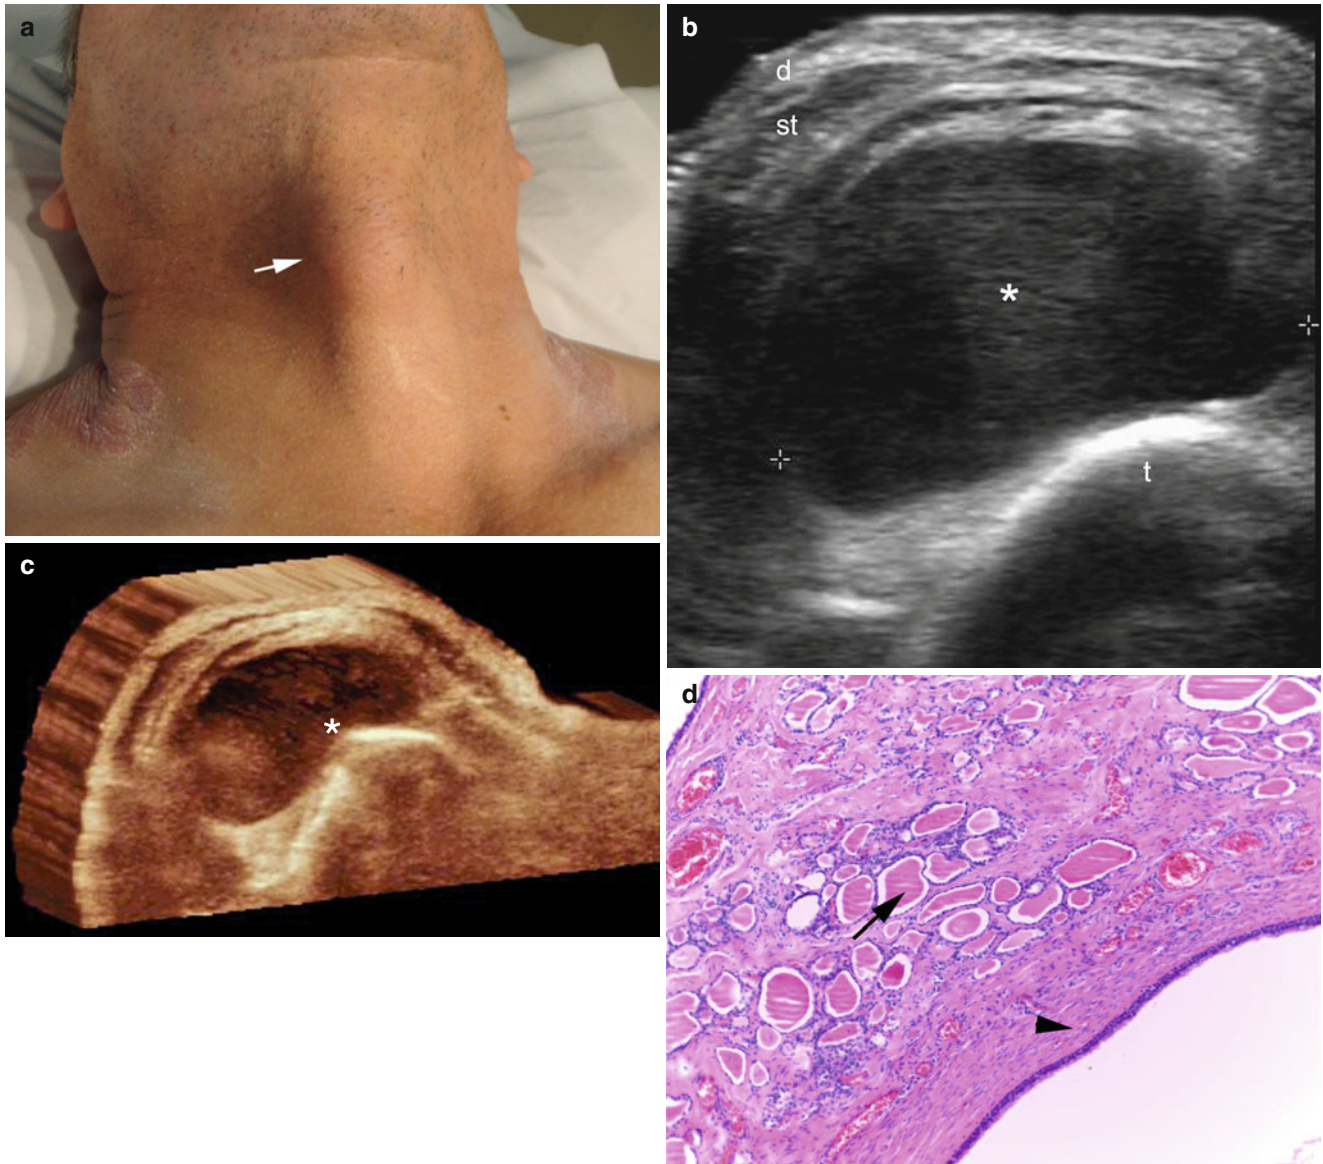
(a–d) Thyroglossal cyst. (a) Clinical image shows a bump in the anterior aspect of the neck in a psoriatic patient. (b) Ultrasound image (gray scale, transverse view) demonstrates a well-defined *oval-shaped* anechoic structure (*, between markers) attached to the anterior aspect of the trachea close to the midline of the neck. (c) 3D ultrasound image
